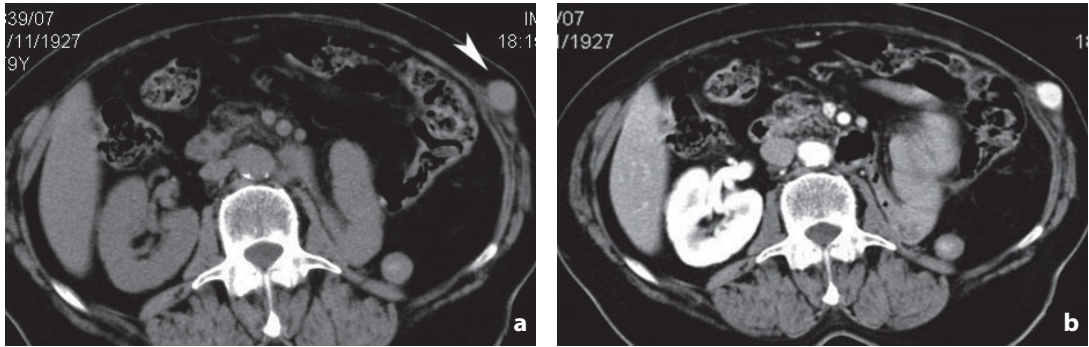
Computed tomography. Axial nonenhanced (a) and enhanced (b) images. Muscle metastasis of renal cell carcinoma following left radical nephrectomy. A solid enhancing nodule (*arrowhead*) can be identified in the left abdominal wall at the level of the oblique muscles
